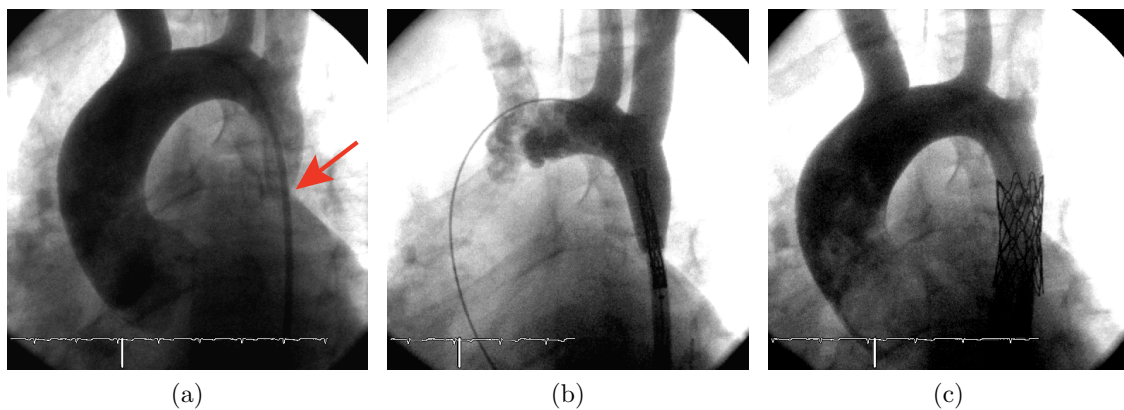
Three steps of an endovascular stenting procedure observed through X-Ray angiography: a) guide-wire within the aorta, with arrow indicating location of coarctation lesion, and injected contrast agent showing the lumen outline; b) stent mounted on a balloon is positioned along the guide-wire to the CoA; c) the expanded stent restores unobstructed flow.
